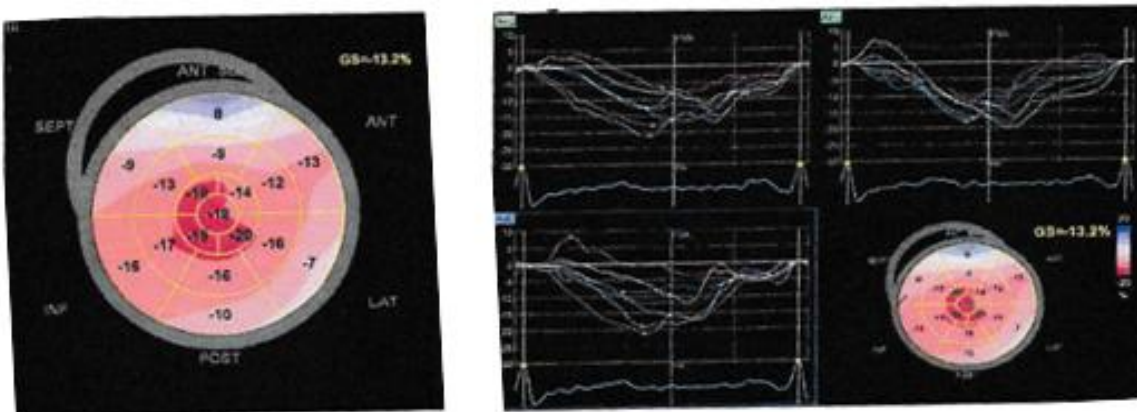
2D speckle tracking echocardiography
